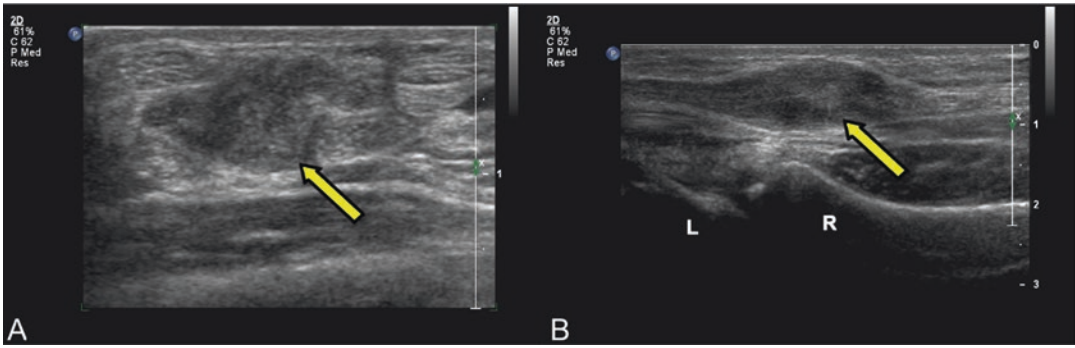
Axial ultrasound image in the axial (a) and sagittal (b) planes—nerve sheath tumor of the median nerve (yellow arrow); R radius, L lunate
